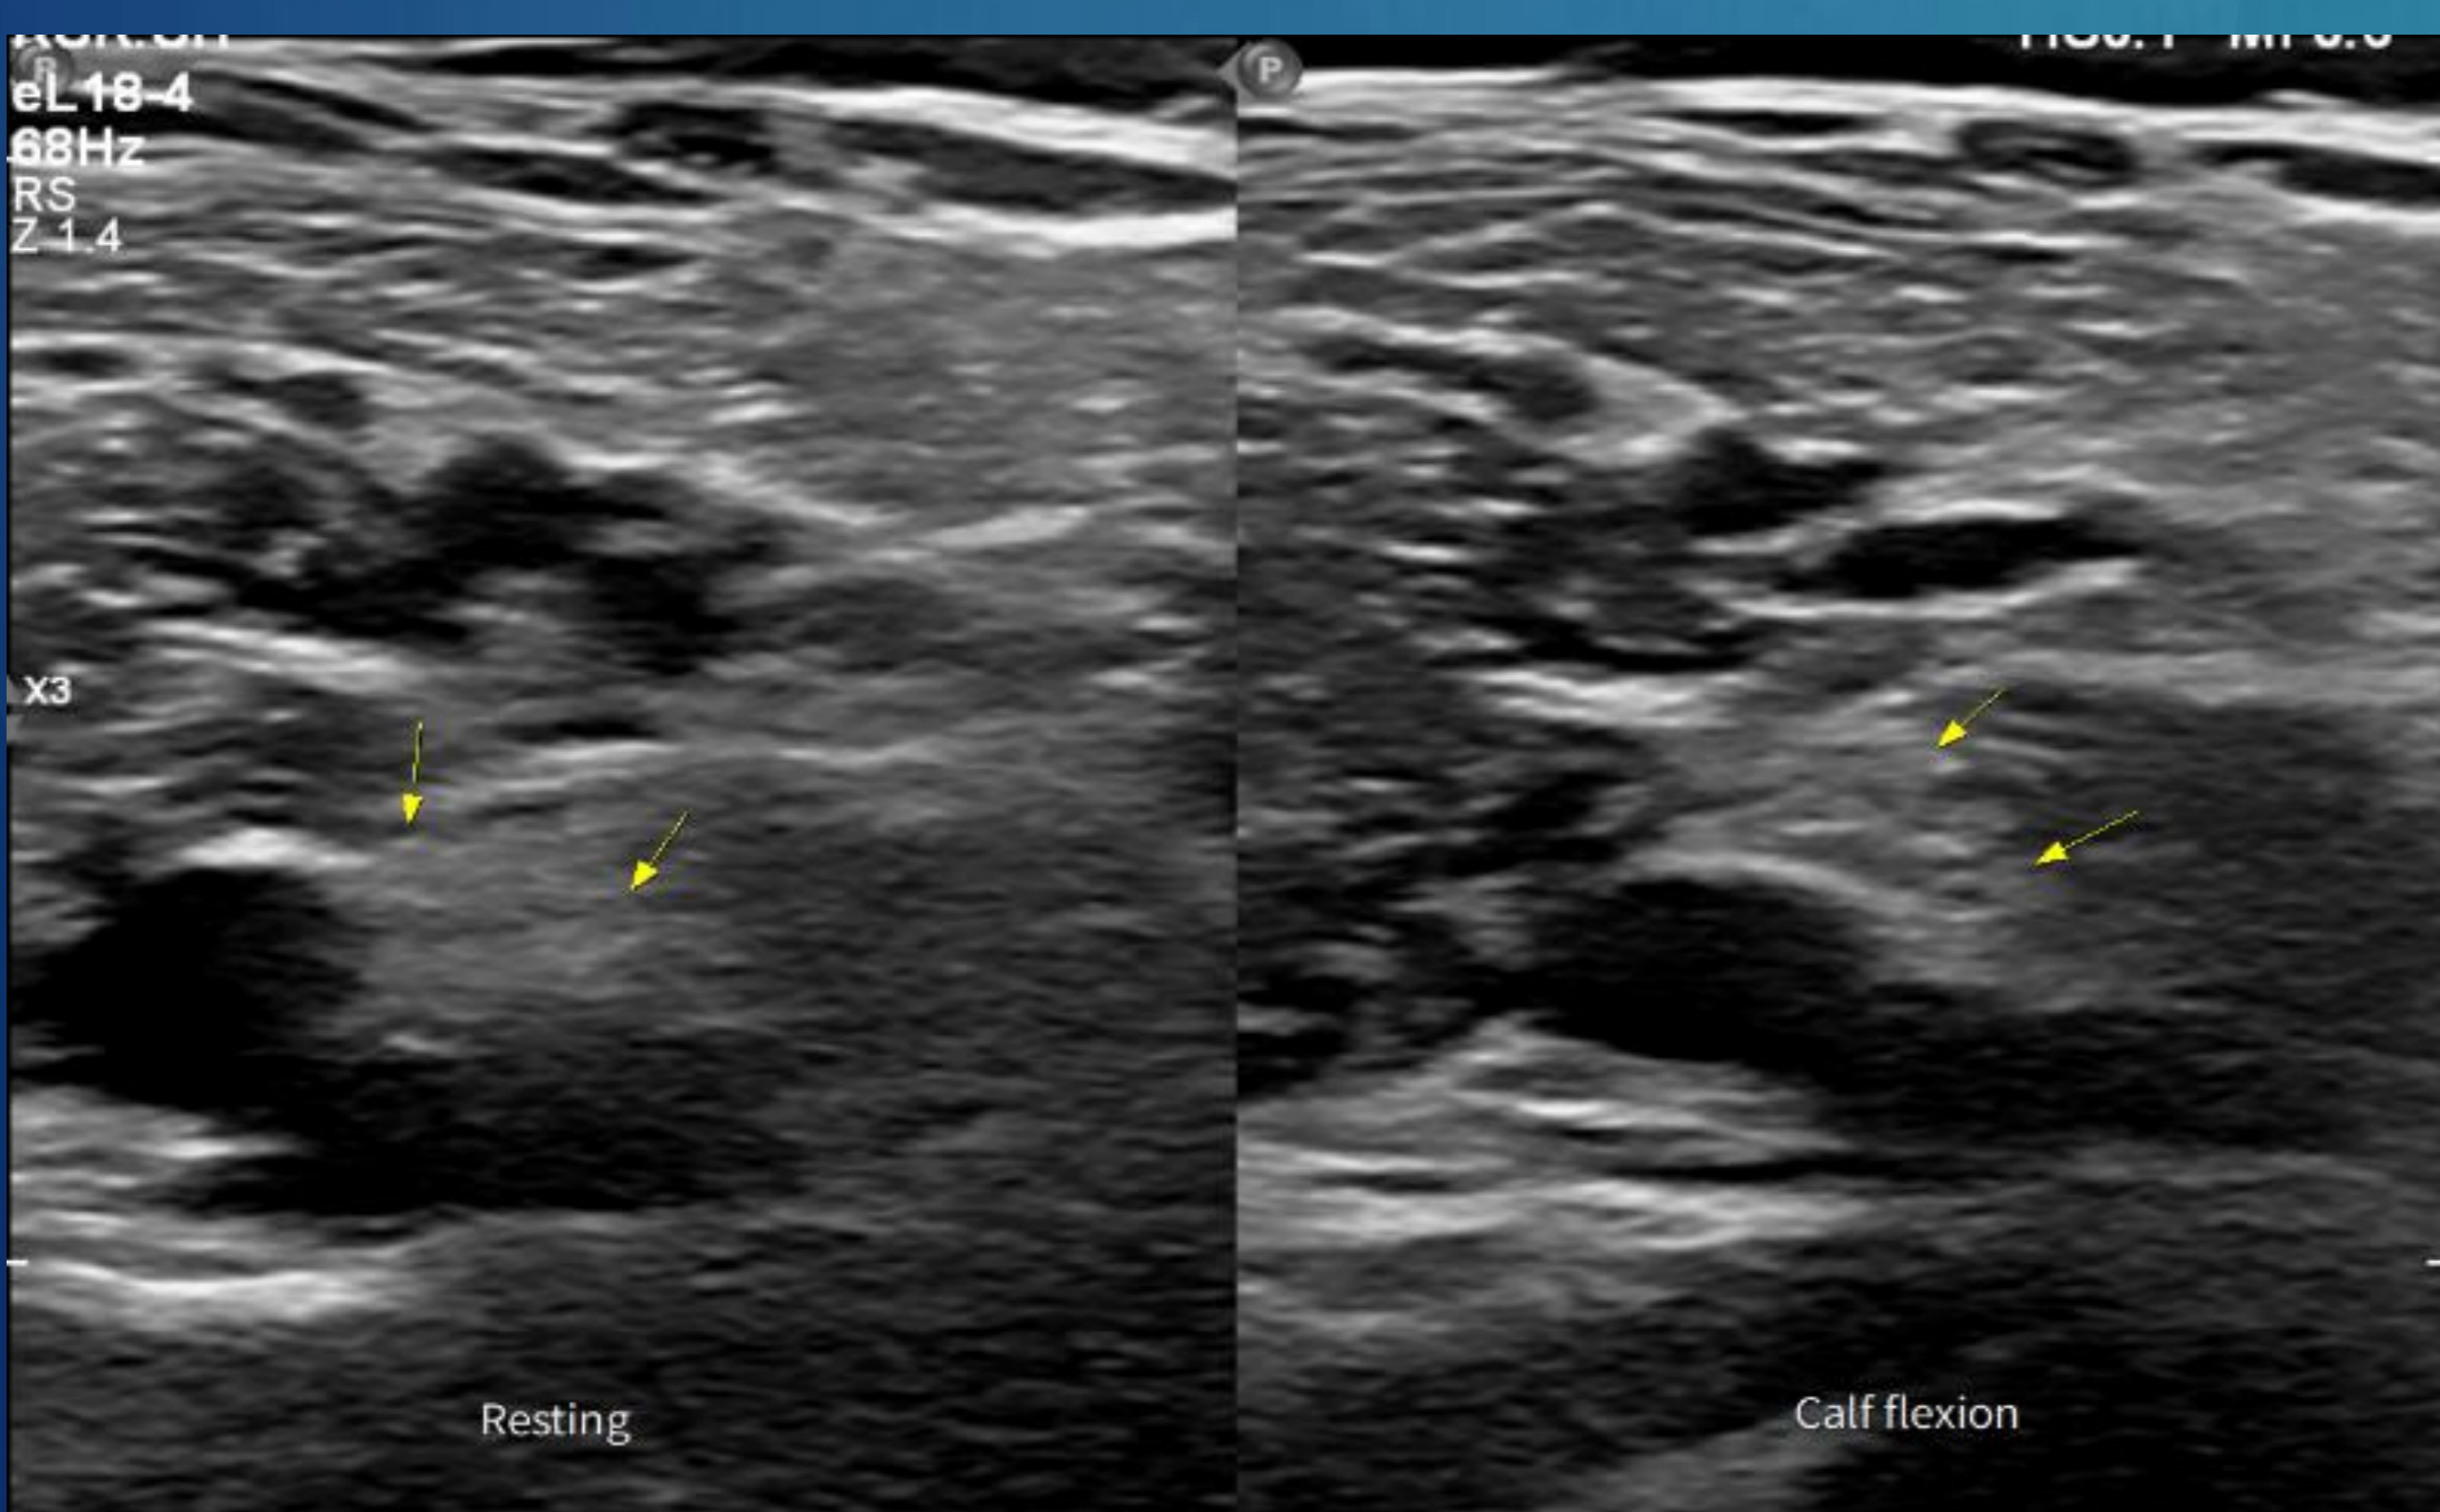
Dynamic doppler ultrasonography of the right lower extremities. During calf muscle flexion, dynamic focal constriction of the tibial nerve caused by the soleal arcade and vascular structures.
